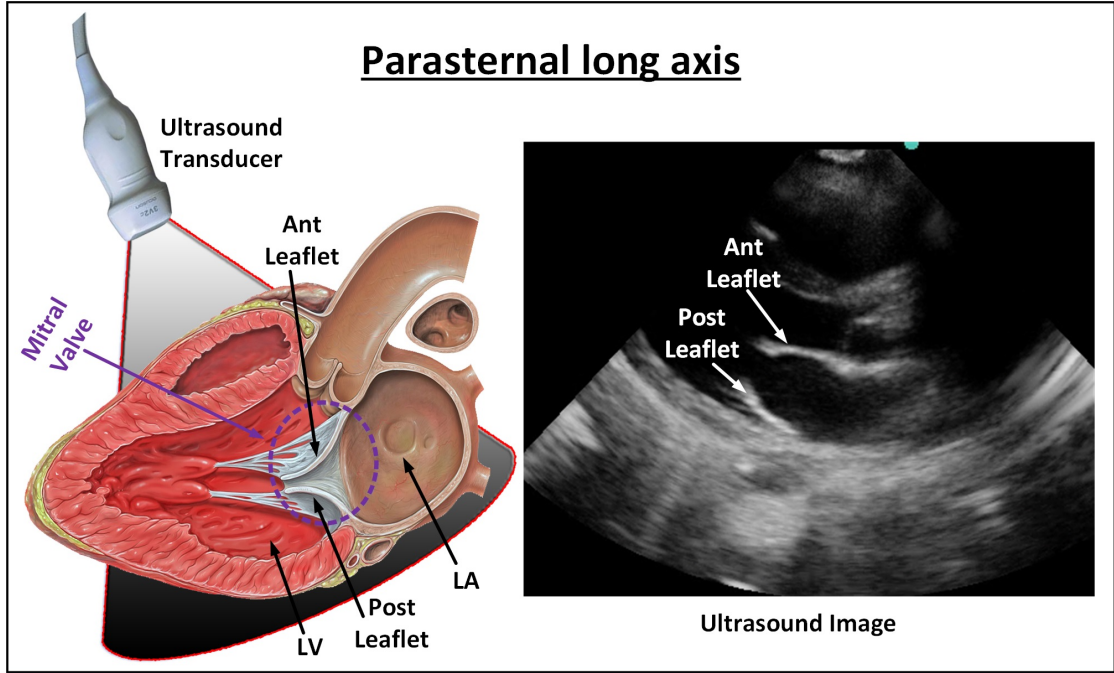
Parasternal long axis view of a normal mitral valve in diastole.
